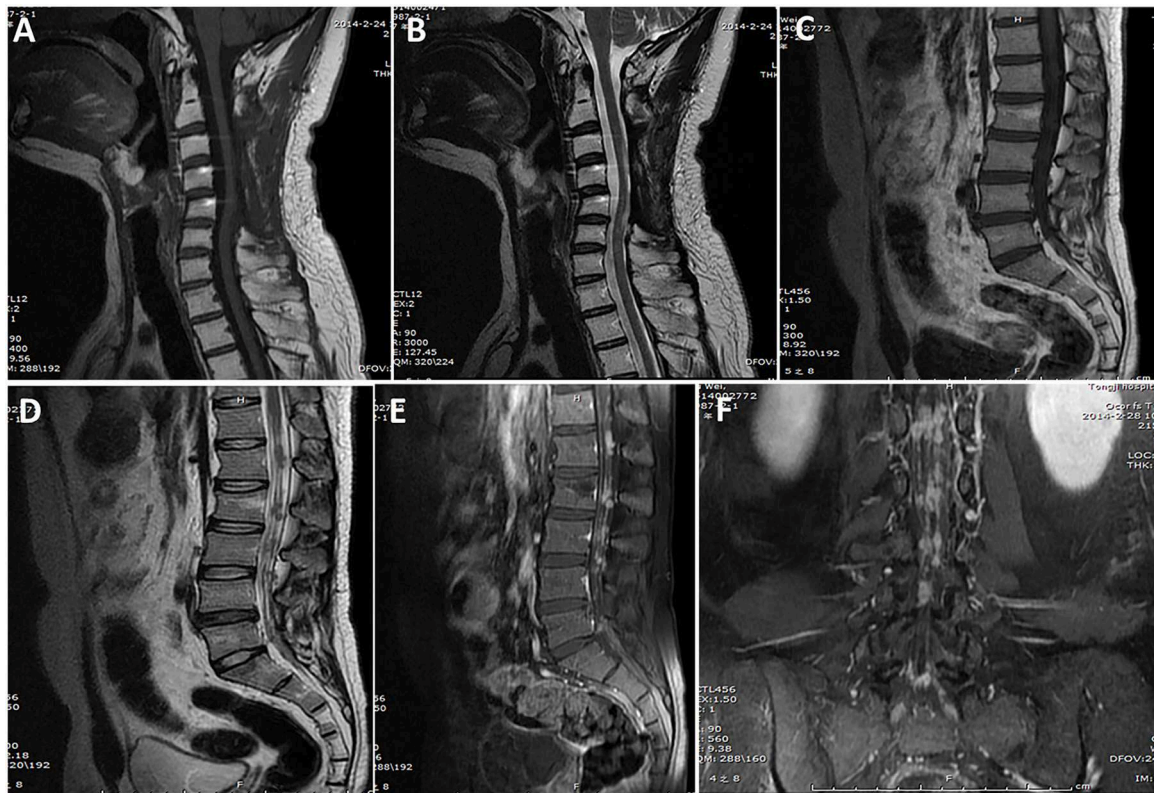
A case of primary intradural ES/pNET at the C3–C5 level. Images obtained 14 months after the first surgery (A,B) showed no tumor local recurrence at the C3–5 level (lack of preoperative MRI examination findings), but they did show multiple metastases in the spinal canal through the cerebrospinal fluid (C–F).
